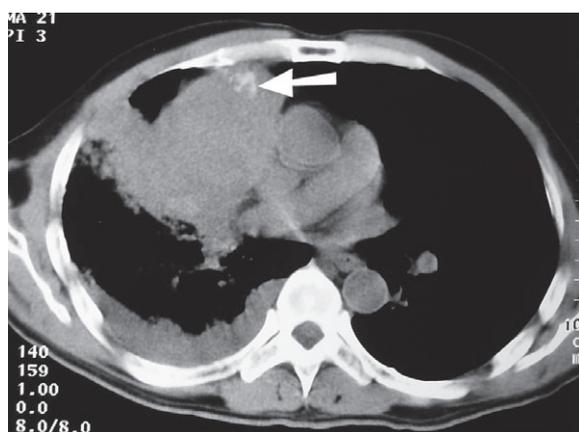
Un-enhanced CT: a large mass of soft tissue density with specks of calcification (arrow), located within the upper lobe of the right lung. Right-sided pleural effusion.
